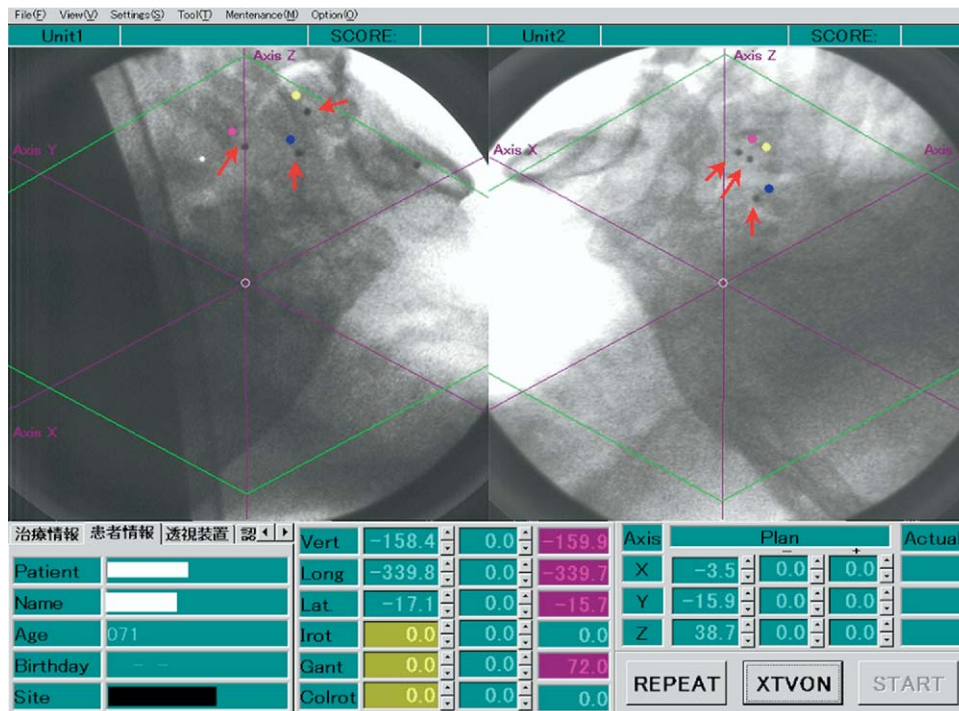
Actual view of real-time tumor tracking radiotherapy system in patient wearing mouthpiece. Actual positions of three markers designated by arrows. Pink, yellow, and blue dots represent planned positions of markers determined during treatment planning computed tomography.
